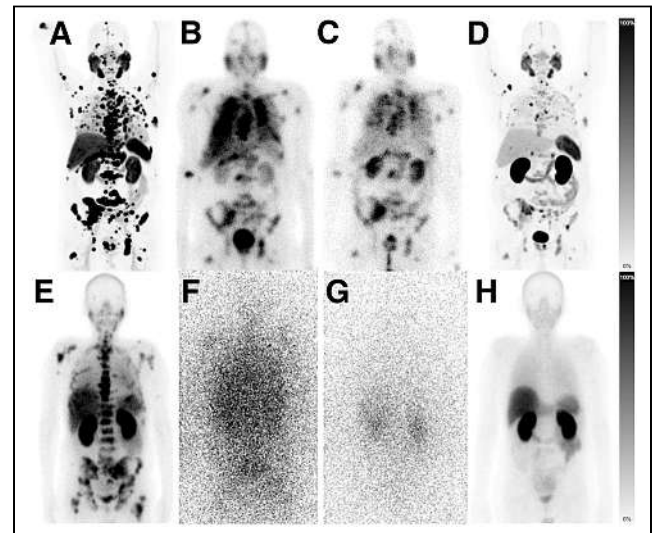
(A–D) Patient with meningeal, adrenal, pulmonary, lymph nodal, and osseous metastases. (A) Baseline staging per ^{18}F -PSMA-1007 PET/CT is demonstrated as maximum-intensity projection. (B and C) Two cycles of AcPSMA and LuPSMA cocktail therapy were documented per planar scan of 208-keV γ -line of ^{177}Lu . (D) PET/CT restaging presents partial remission. (E–H) Patient with adrenal, osseous, lymph nodal, and hepatic metastases. (E) Baseline imaging was done as planar $^{99\text{m}}\text{Tc}$ -PSMA scintigraphy. (F and G) AcPSMA monotherapy was documented per planar emission scans using 26% 440-keV and 12% 218-keV γ -coemissions of ^{213}Bi and ^{221}Fr . (H) Restaging per planar $^{99\text{m}}\text{Tc}$ -PSMA scintigraphy demonstrates near-total remission.
